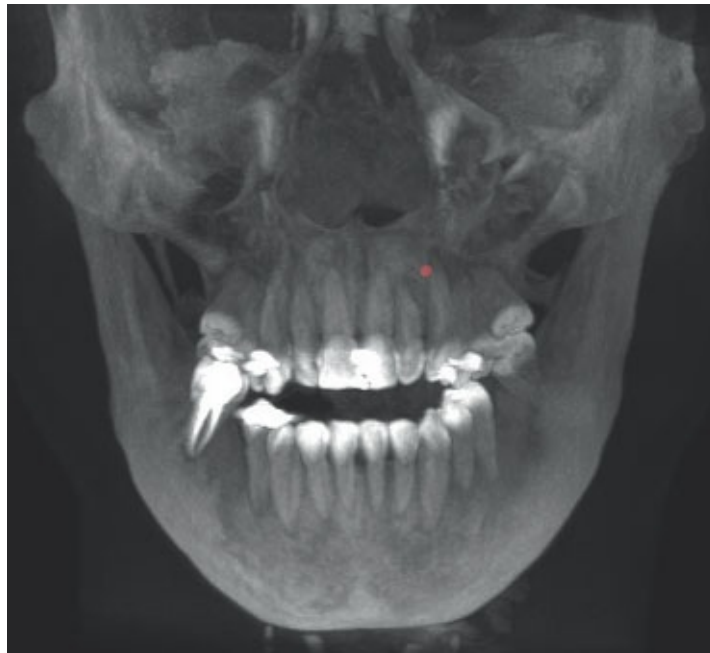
• Cone-beam computer tomography showing maxillary transverse deficiency.
